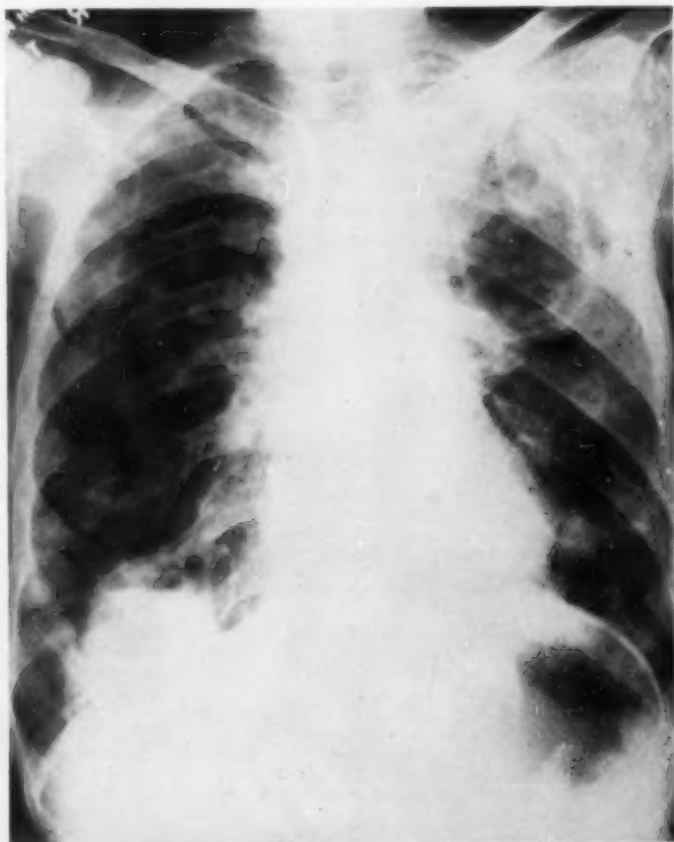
X-ray of June 16, 1956, shows multiple metastases of both lungs with many nodules showing central highlight. There is a large cavity in the left upper lung field (breakdown of the primary bronchogenic neoplasm) and a large mass with cavity and fluid level in the right base (breakdown of a large metastatic focus).
